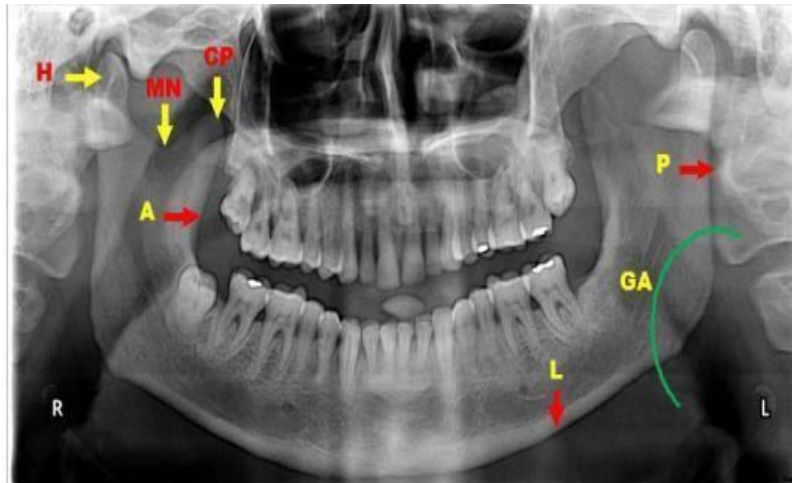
Orthopantomograph used in the study showing various anatomic landmarks of mandible:- L-Inferior border of mandible, P-Posterior border of ramus, GA-Gonial/mandibular angle, H-Head of mandible, A-Anterior border of ramus, MN-Mandibular Notch, CP-Coronoid Process
